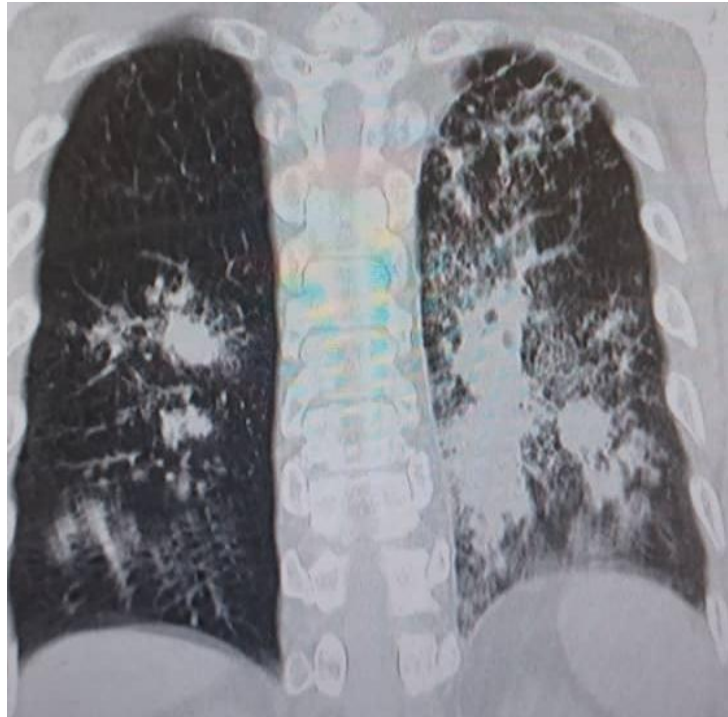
Computed tomographic (CT) chest scan (coronal view) during admission.
